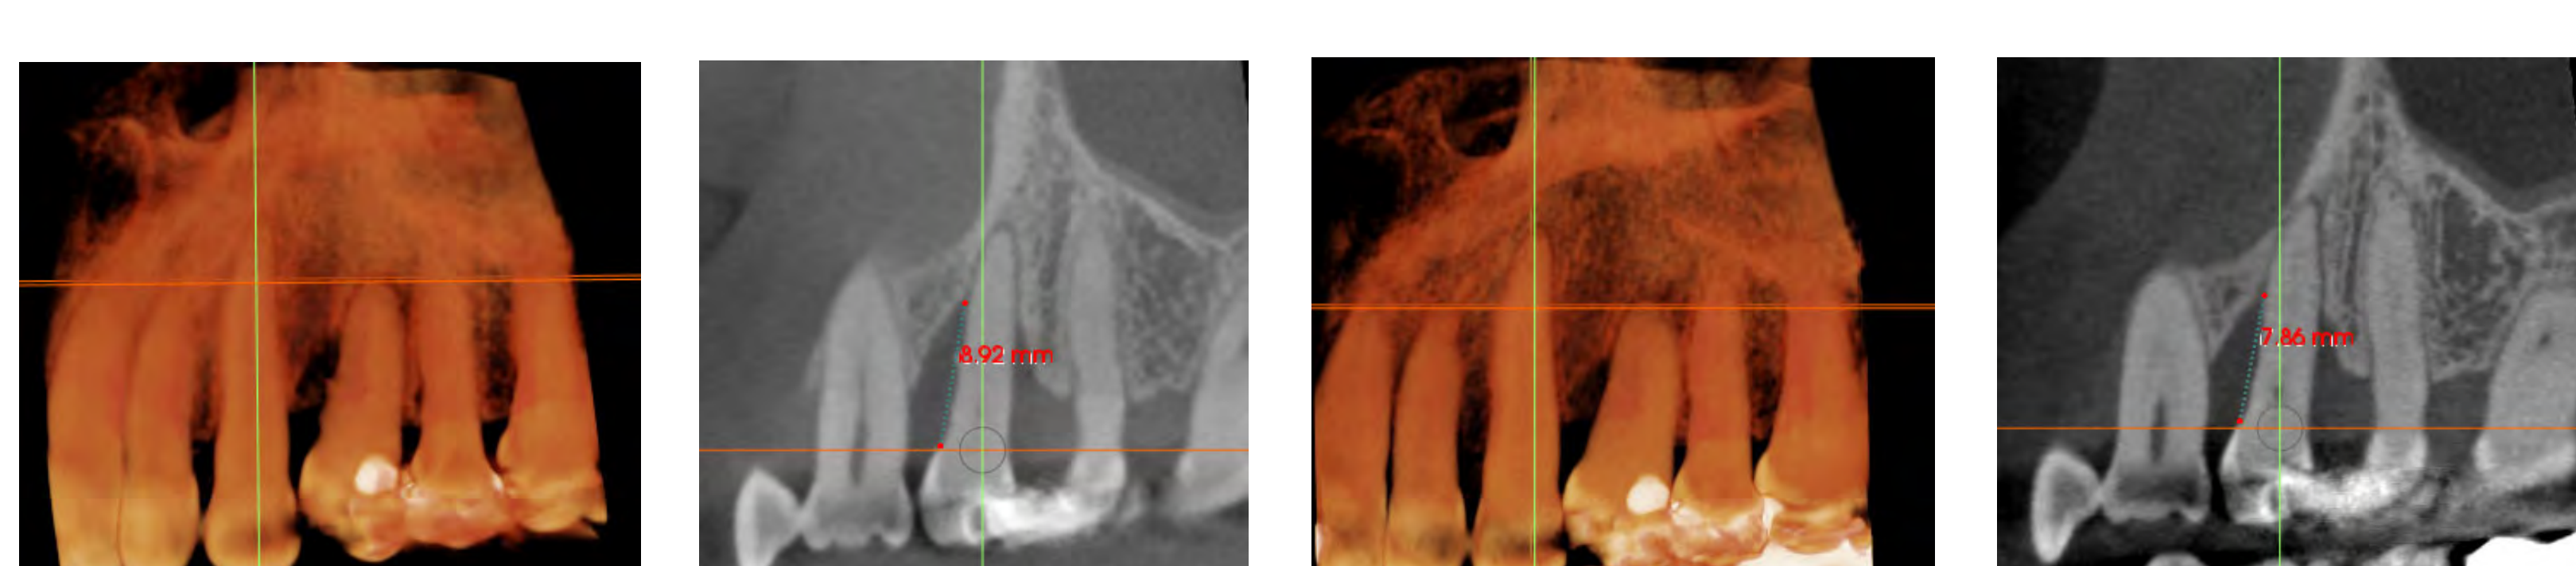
(A) CBCT bony defect mesial aspect tooth 12 at T1, SRP+LASER. (B) CBCT defect measurement mesial aspect tooth 12 at T1, SRP+LASER. (C) CBCT bony defect mesial aspect tooth 12 at T2, SRP+LASER. (D) CBCT defect measurement mesial aspect tooth 12 at T2, SRP+LASER.
